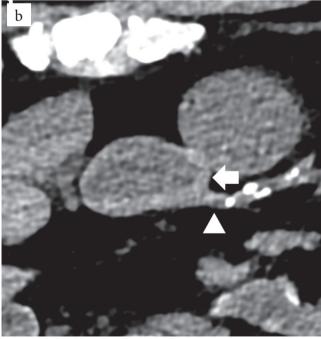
Postmortem computed tomography. The thickening of the aortic wall (arrow) was observed at the Valsalva sinus under the left main trunk of the coronary artery (arrowhead): a) Sagital and b) axial image.
